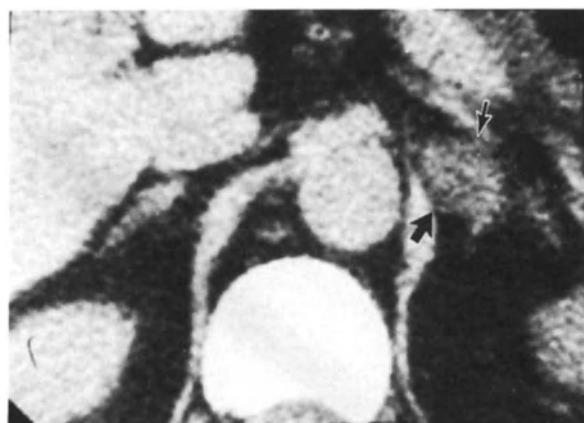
CT scan. Conn's tumor left adrenal (arrows).
